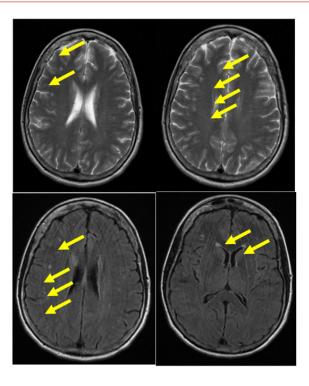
MRI with contrast.
